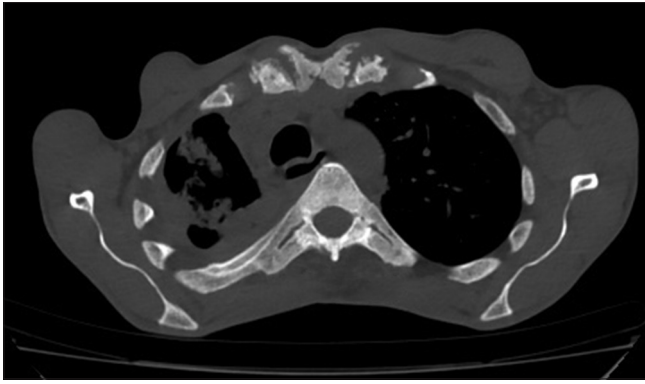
Axial CT image of thorax showing arthropathy with ankylosis at costotransverse and costovertebral joints. Smooth periosteal thickening in rib on the right side. Also noted osteitis and arthropathy bilateral sternoclavicular joint. Note: Right lung cavitary lesions with intracavitary fungus balls - the patient was referred for pulmonary symptoms
